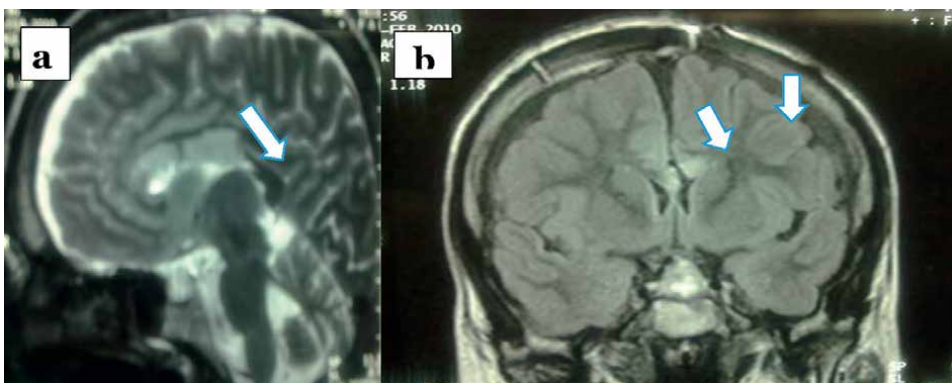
Corpus callosotomy; (a); brain MRI, coronal section T1 weighted, showing the disconnection of the corpus callosum (one row), (b); brain MRI sagittal section T2-weighted showing anterior 2/3 of the disconnection of the corpus callosum (2 rows).
